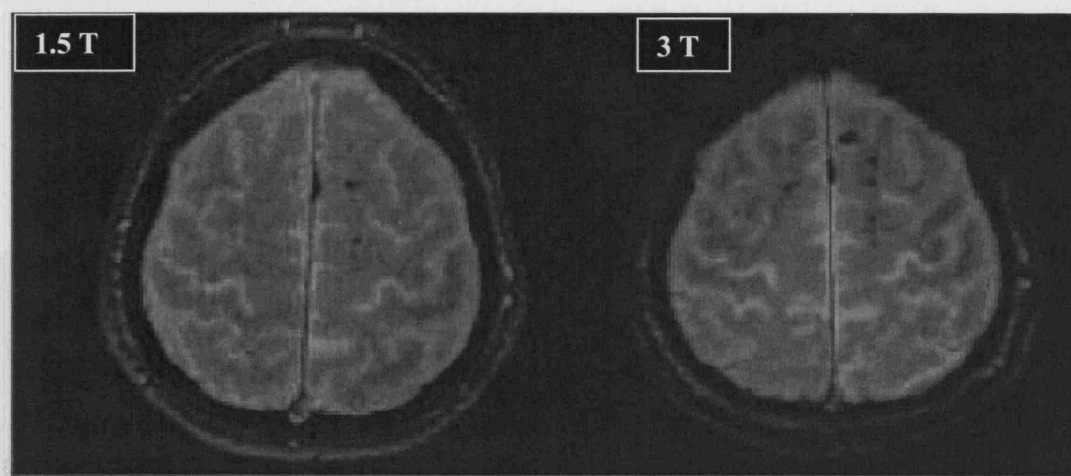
Brain microbleeds on 3T GRE MRI and 1.5T GRE MRI
